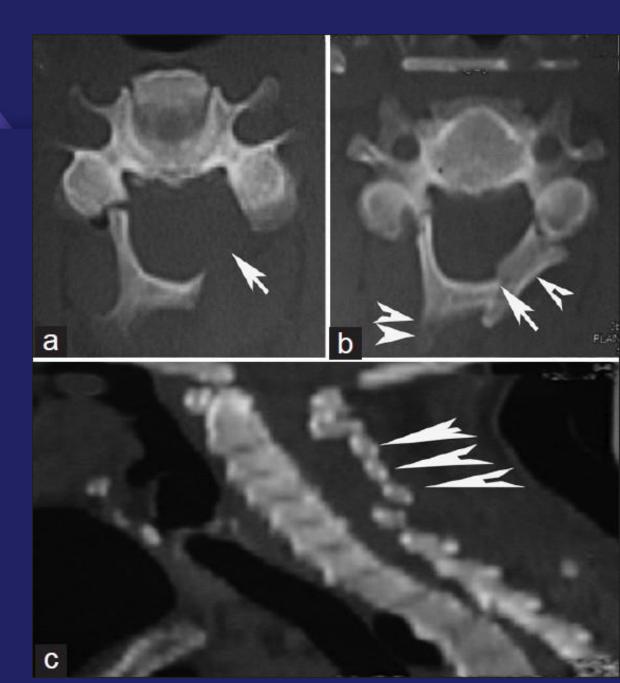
Axial computed tomographic scans obtained at the C5 level. A, preoperative scan showing a narrowed sagittal bony canal diameter. B, scan obtained after laminoplasty with rib allograft. C, scan obtained 2 years later. Note arthrodesis and reconstruction of the posterior bony arch.
